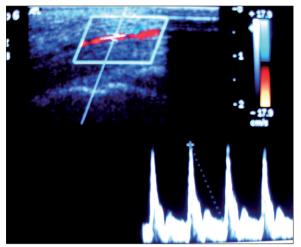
Pulse Doppler one week after anticoagulant therapy shows improving spectral flow pattern and velocities.
